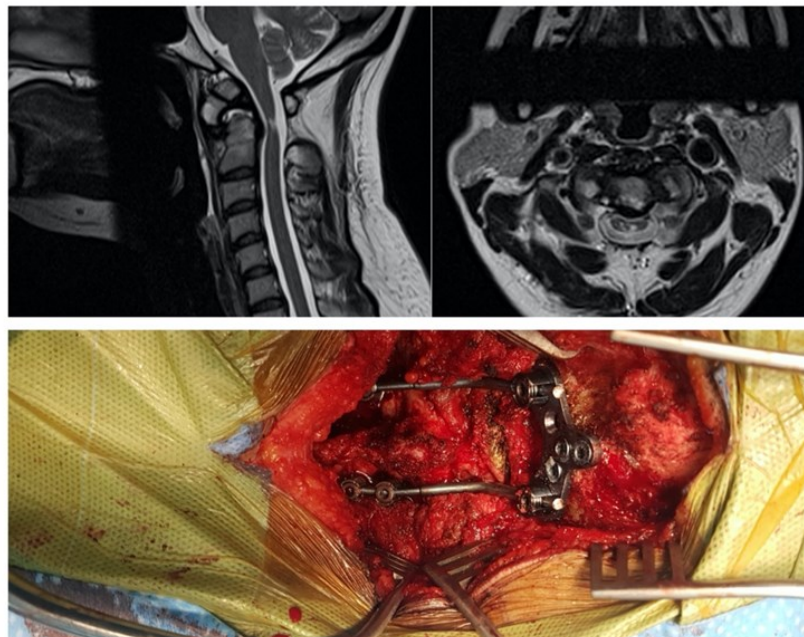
Top – T2 MRI sequence showing myelomalacia of upper cervical cord (bright spot posterior to dens). Bottom – final intraoperative occipito-cervical construct.
